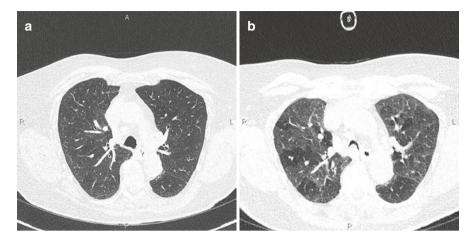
(a) HRCT of the lungs during inspiration, the apparent GGO phenomenon dorsally. The rounded shape of the trachea confirms inspiration. (b) The same patient, in the same layer done in expiration, where the GGO are highlighted in the dorsal parts, although noted slightly ventrally, where there is in addition the left paramediastinal "air trapping", i.e. pathological retention of air in a certain area of the lungs. The expiration confirms the concavity of the dorsal wall of the trachea
